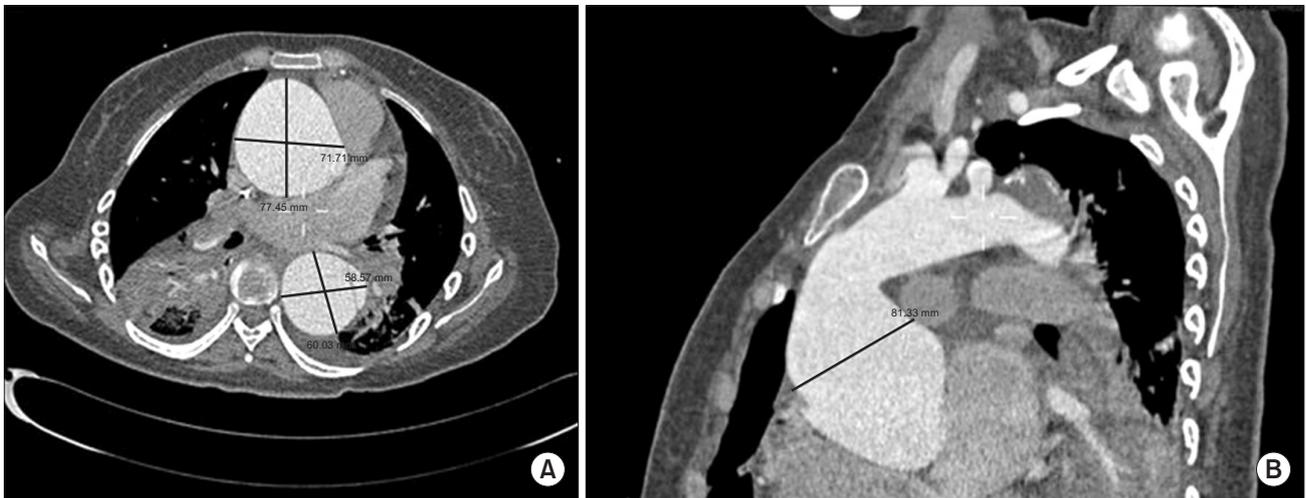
Chest computed tomography angiography demonstrates the maximum diameters of the ascending aorta in (A) axial view (7.74 cm) and (B) lateral view (8.13 cm).
